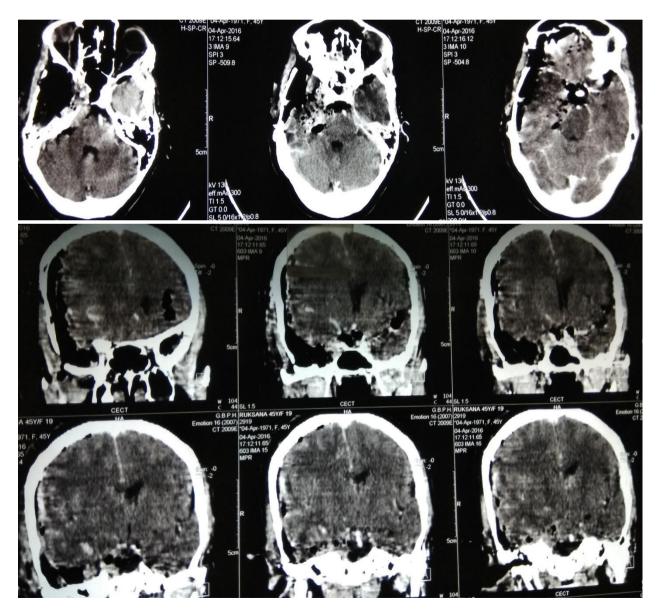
Contrast CT (axial and coronal) post-operative images of the patient done 1 year back, showing gross total resection of meningioma.
